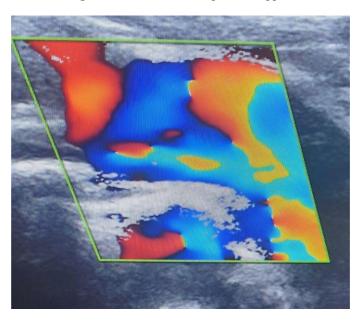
Venous flow on Color Doppler
